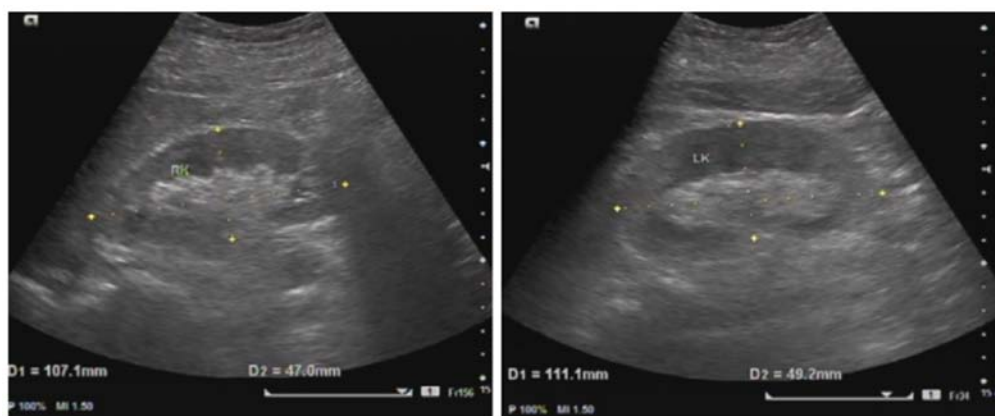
Ultrasound of a slightly hyperechogenic renal cortex and kidneys with no stones.
